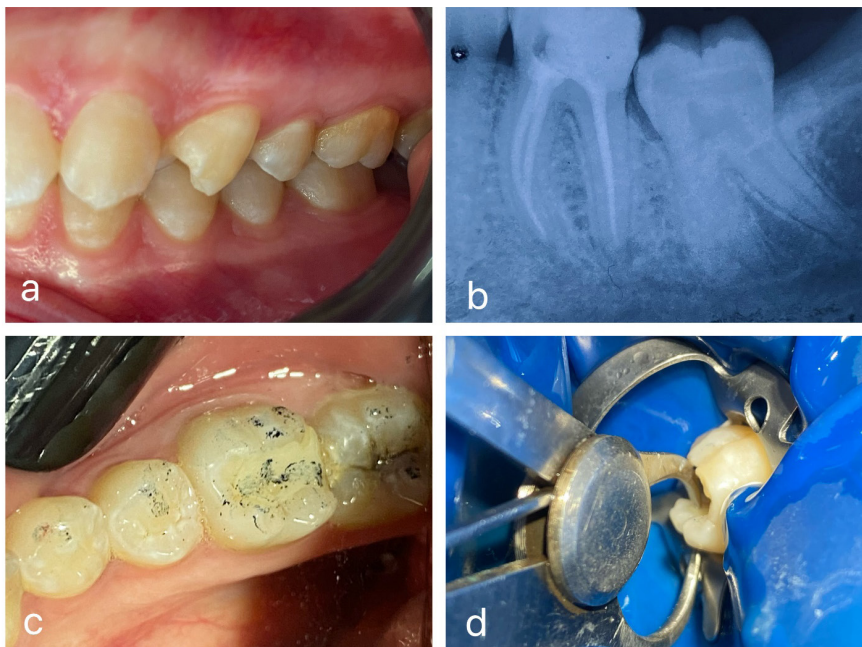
(a) Occlusion in left lateral view; (b) preoperative periapical x-ray; (c) Intraoral picture of the preoperative condition of the 36 and marking the occlusal contacts with 80 μ m articulating paper; (d) measuring the thickness of the residual wall: less than 2 mm.
